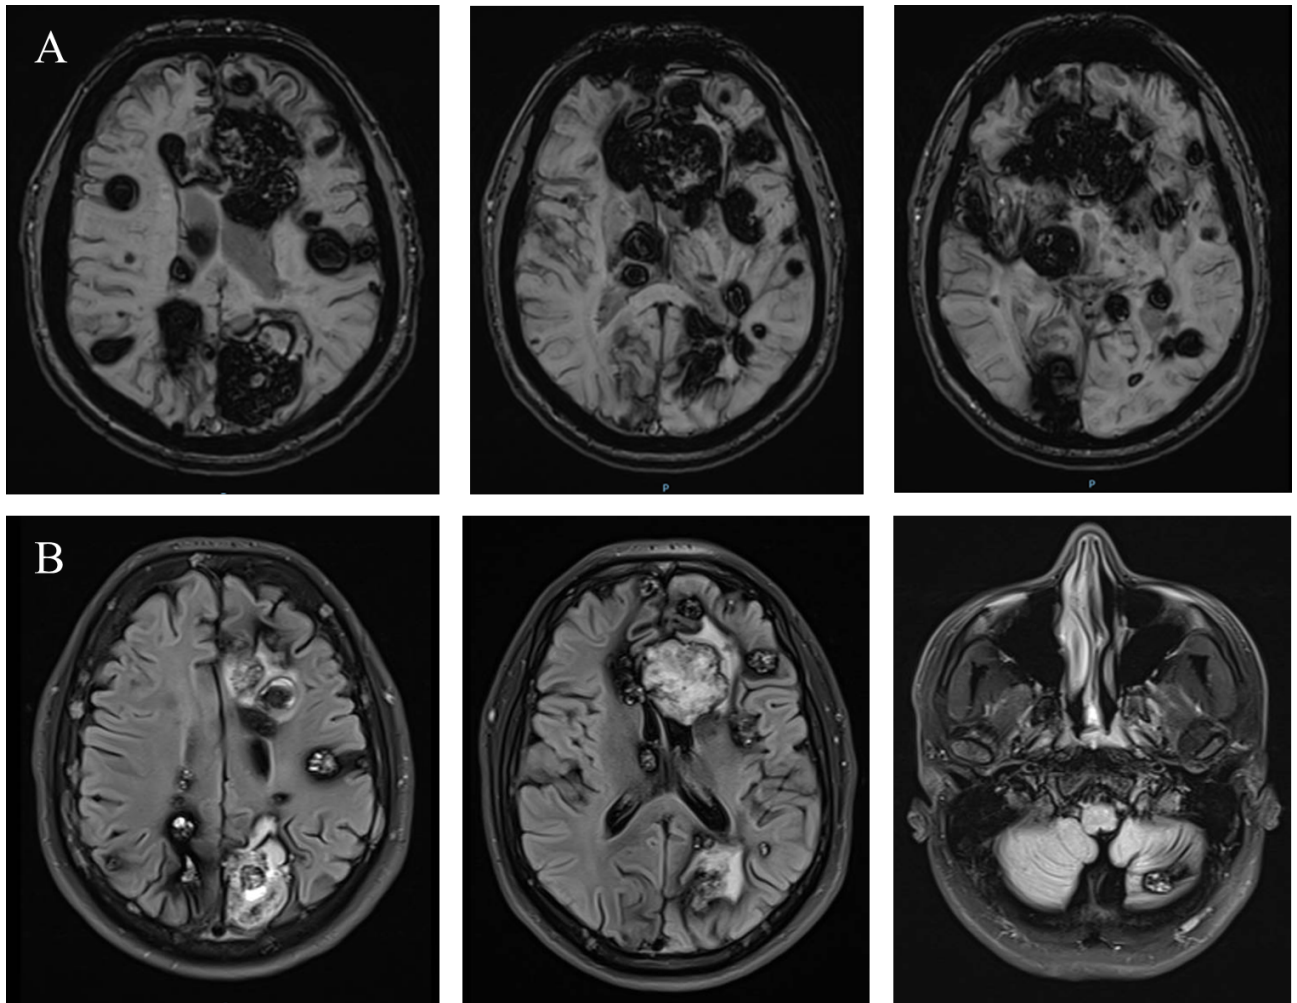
MRI. SWAN sequence (A) demonstrates the signal loss typical of cavernomas. FLAIR (B) shows the characteristic popcorn appearance of cavernomas.
